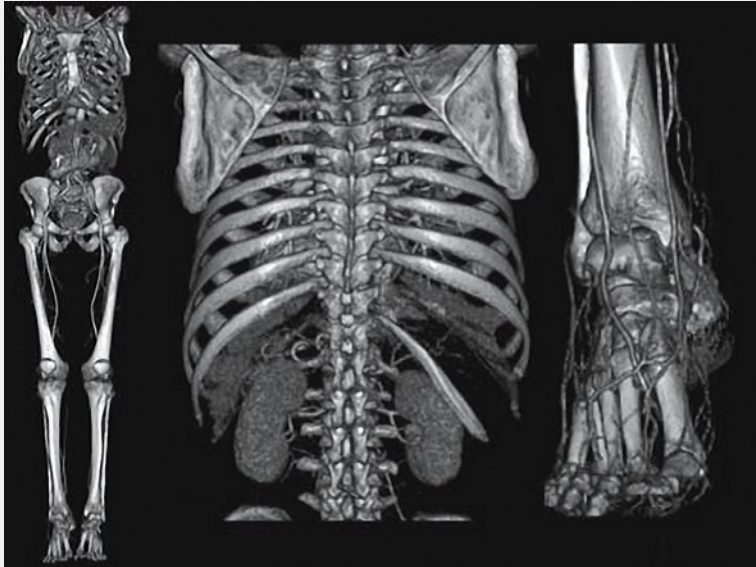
Whole-body images taken using a CT scanner [2]
